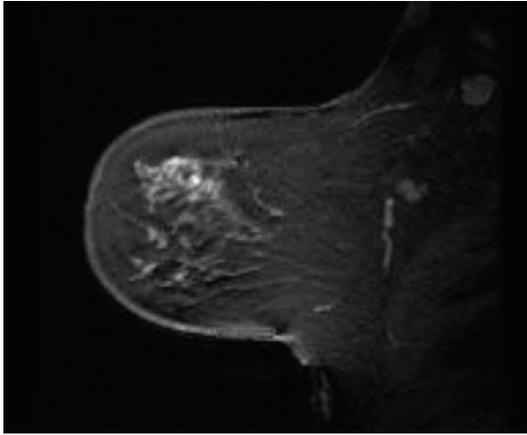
MRI appearance of recurrent DCIS.
